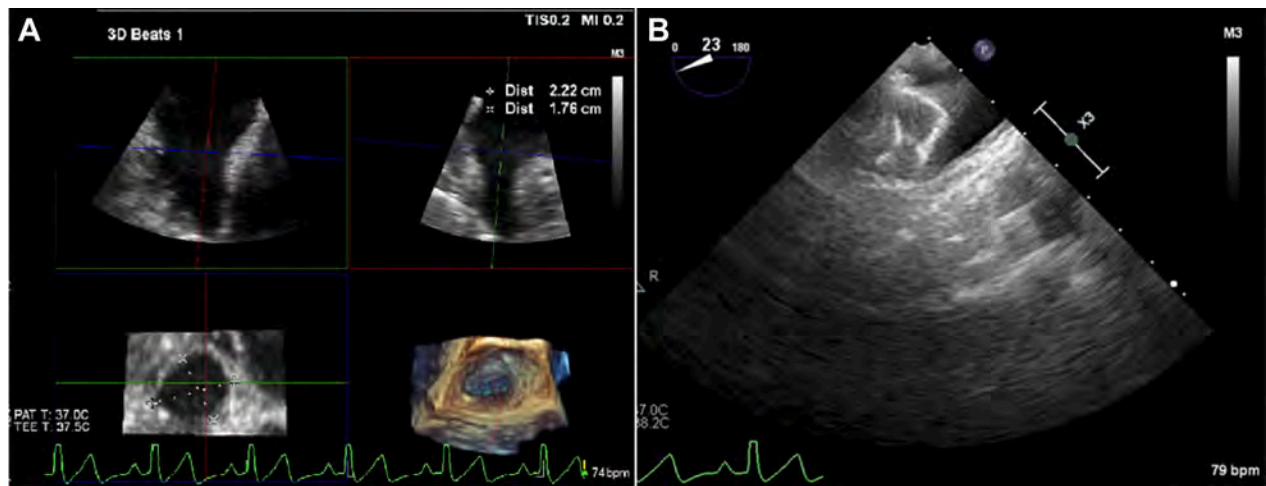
Fluoroscopy and Transesophageal Echocardiography Images Showing Amulet Device Placement
